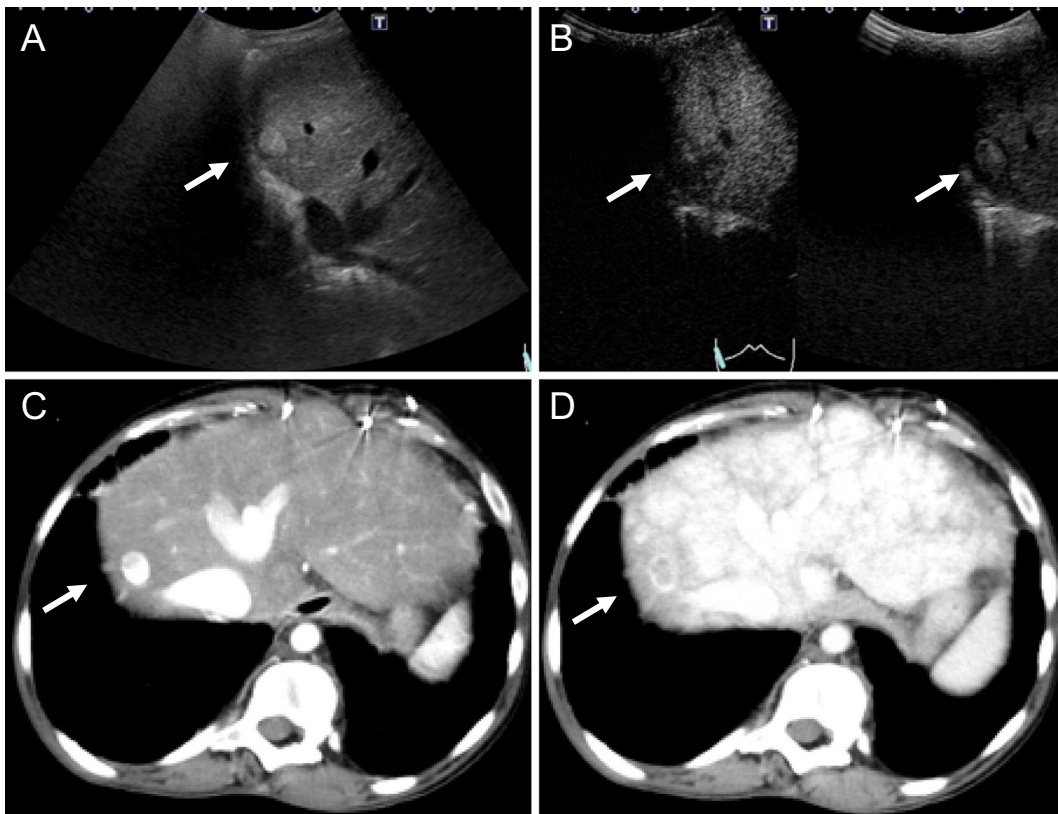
Abdominal ultrasonography showing a hepatic nodule 15 mm in size at the right lobe, a dull edge in the liver, and a dilated hepatic vein (A). Contrast-enhanced ultrasonography showed a lesion 15 mm in size with enhancement in the early phase, washout in the vascular phase and a defect pattern in the post-vascular phase (B). Dynamic computed tomography of the abdomen showed a round lesion 15 mm in size at segment 8 that had arterial enhancement (C) and washout in the portal phase with delayed peripheral enhancement and a non-homogeneous pattern of hepatic enhancement in the portal vascular phase due to congestive liver (D).
